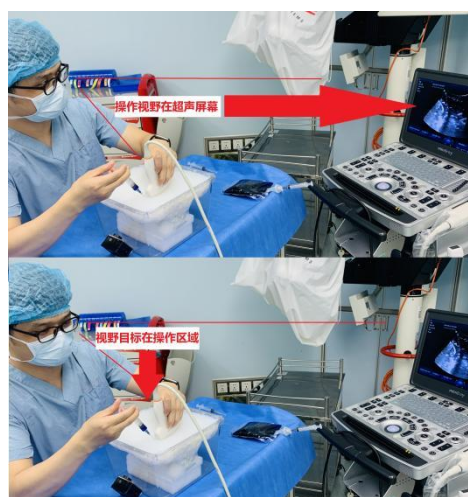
Conventional Ultrasound-Guided Field Switching Method
